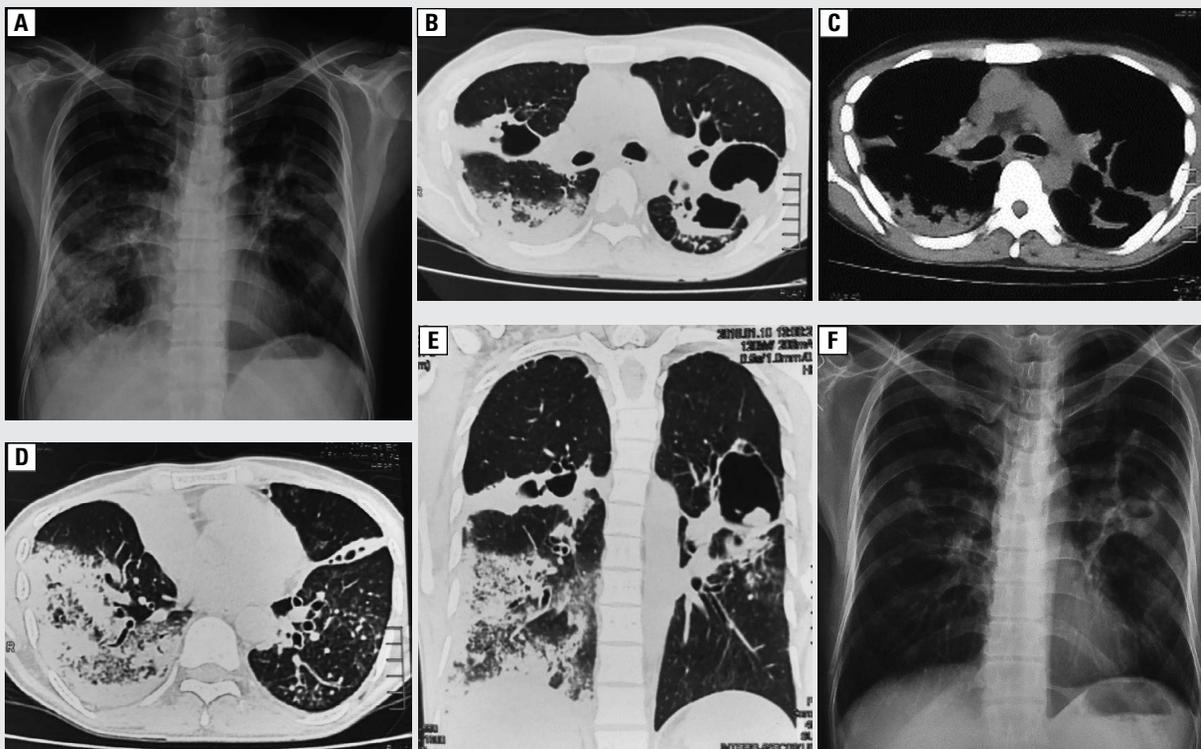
A. Chest X-ray showing bilateral cavitary lesions with right lower zone opacities; B–E. CECT chest suggestive of bilateral cavities with a fungal ball in the left upper lobe cavity. Also, bilateral dense alveolar opacities are present and are more prevalent in the right lower lobe; F. Chest X-ray showing resolution
